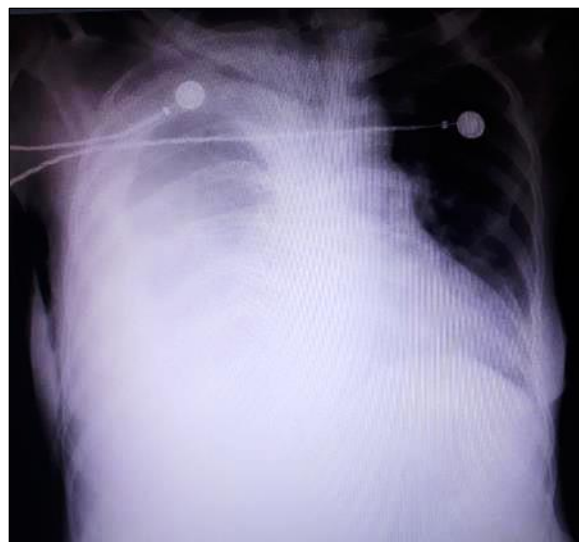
Chest X-ray on the day of admission, showing right-sided massive pleural effusion.
